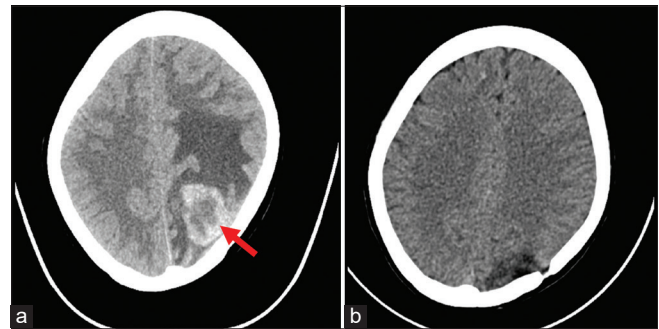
(a) Cranial computed tomography scan prior to craniotomy with a peripherally enhancing lobulated mass in the left parietal lobe, 3.2 cm × 3.4 cm × 3.7 cm (red arrow); (b) S/P excision of left parietal mass
